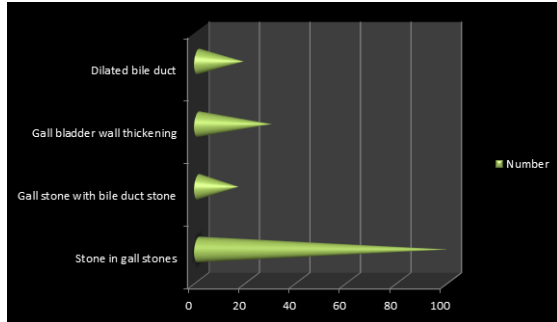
Various Ultrasound Imaging Findings.
